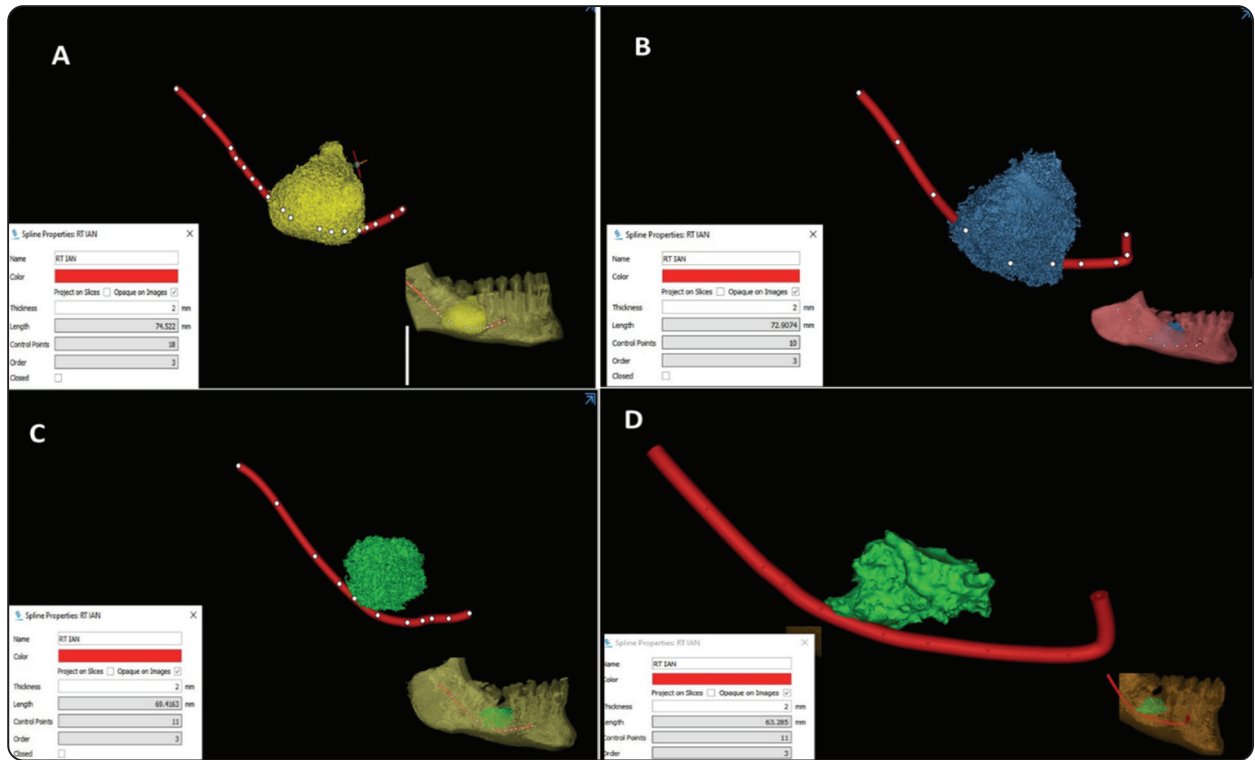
Segmented CBCT images representing the gradual decrease in the IAN length with the decrease of the cyst volume during follow up periods: A) preoperative. B) 3months postoperative. C) 6 month postoperative. D) 9 month postoperative.
